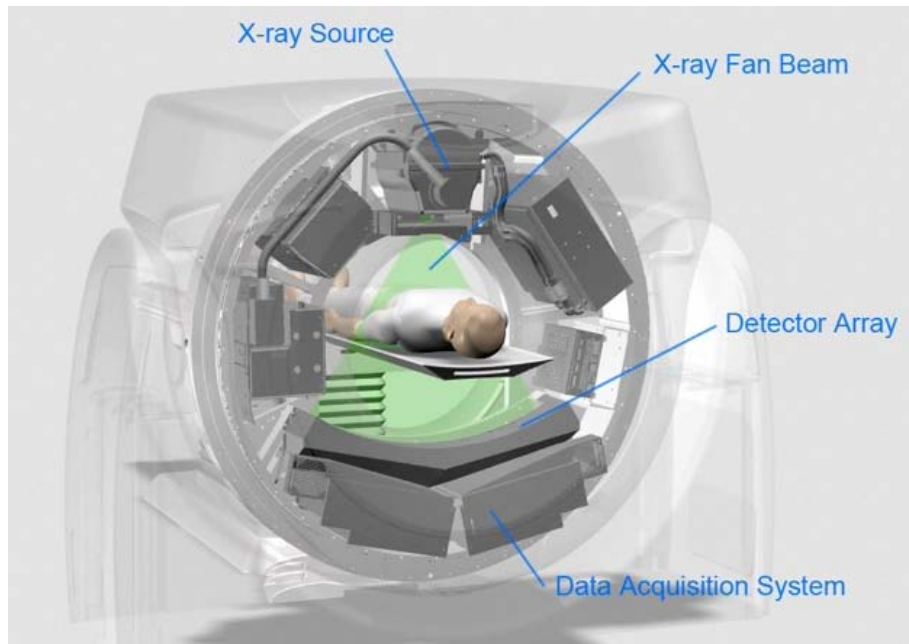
The x-ray tube and the detector array are oppositely placed, inside the gantry. From [45].
